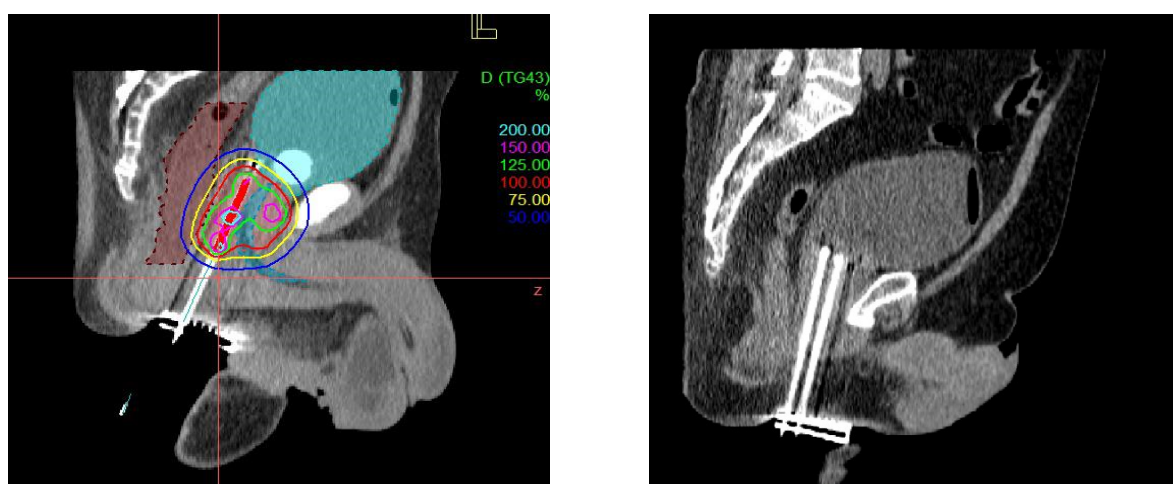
Sagittal CT confirms the intracavitary–interstitial brachytherapy implant geometry, showing multiple interstitial needles traversing the pelvis and their depth relative to pelvic anatomy. Sagittal CT complements this by verifying applicator/needle trajectory and insertion depth, ensuring correct positioning before (and during) treatment planning
